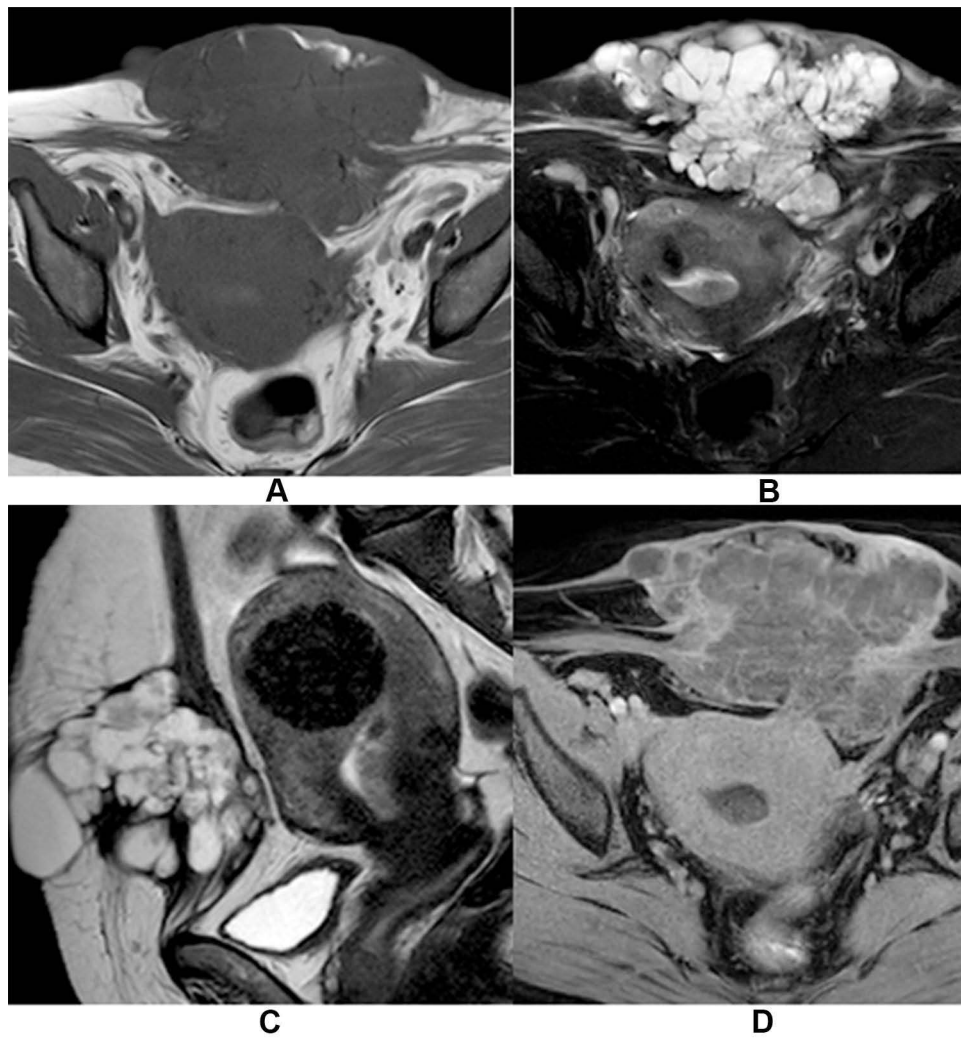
The MRI show the extensive lobulated cystic components of the mass with low signal on T1WI (A) and high signal intensity on T2WI (B–D). Axial post-contrast image showed the solid septal component was significantly enhanced.
